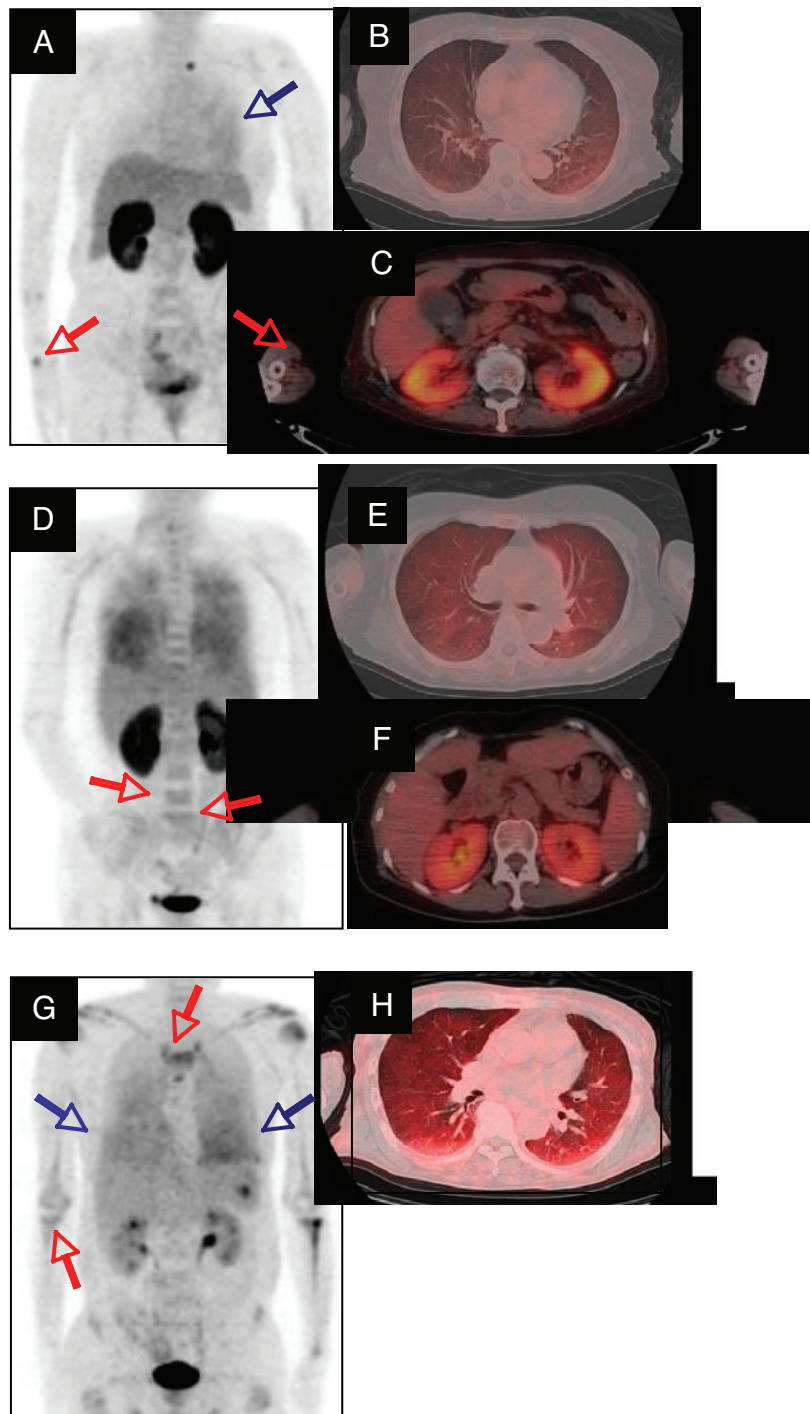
Positron emission tomography/computed tomography findings in patients with intra-vascular large B-cell lymphoma. A-C, Uptake of 18F-fluorodeoxyglucose (FDG) in the bilateral lung of a 74-year-old man, especially diffuse accumulation in the left lung field (A [blue arrows] and B), accumulation in the bilateral renal cortex (C), and multiple accumulations in the bones (A [red arrows]). D-F, Uptake of FDG with diffuse and intense accumulation in the bilateral lung of a 69-year-old woman (D and E), accumulation in the bilateral renal cortex (F), and multiple accumulations in the bones (D [red arrows]). G-H, Uptake of FDG with diffuse accumulation in the bilateral lung of a 64-year-old man, especially in the lower lung field (G [blue arrows] and H), and multiple accumulations in the bones (G, red arrows). FDG uptake was not observed in the bilateral renal cortex (G).
